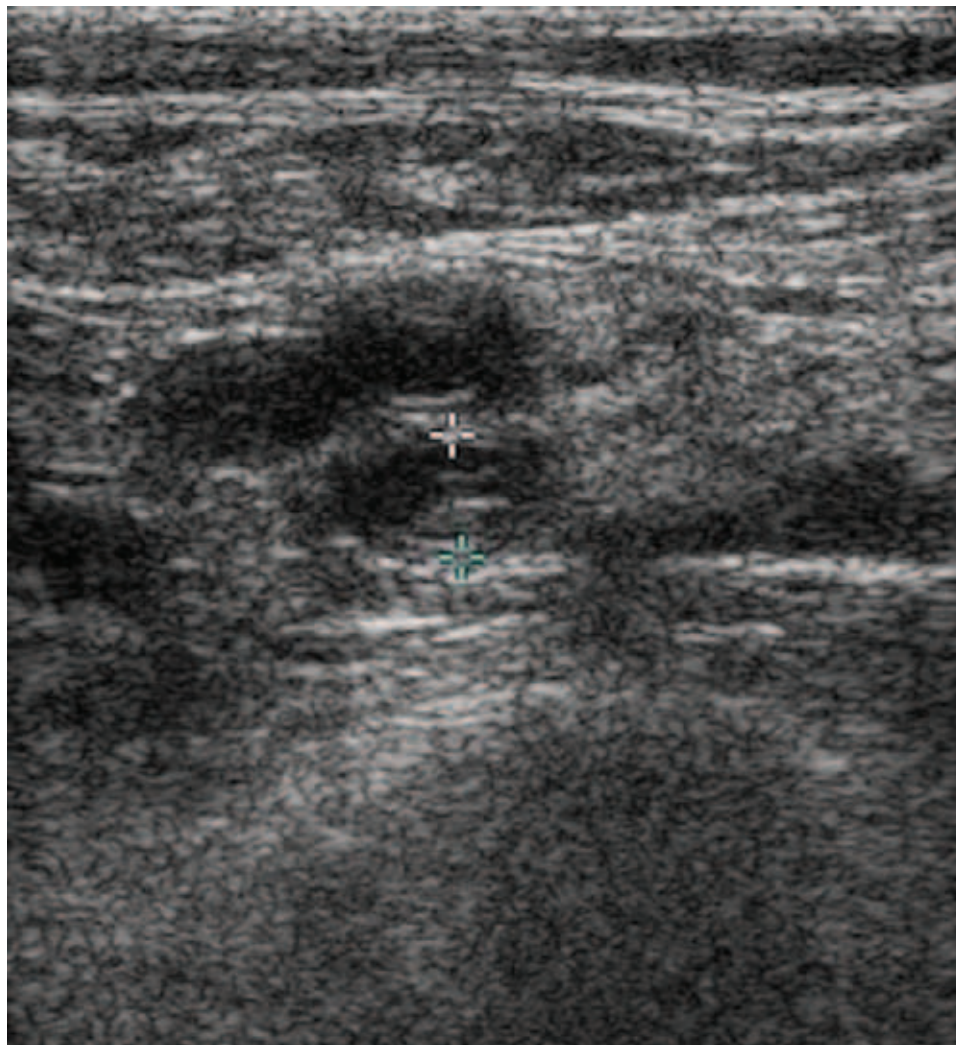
Ultrasound image of a femoral vein deep vein thrombosis (*markers*).
